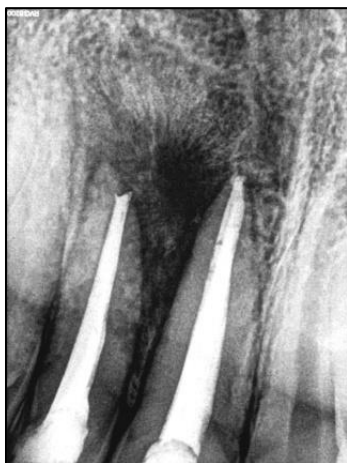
6 months follow up radiograph showing periapical bone formation and decrease in the size of lesion.
